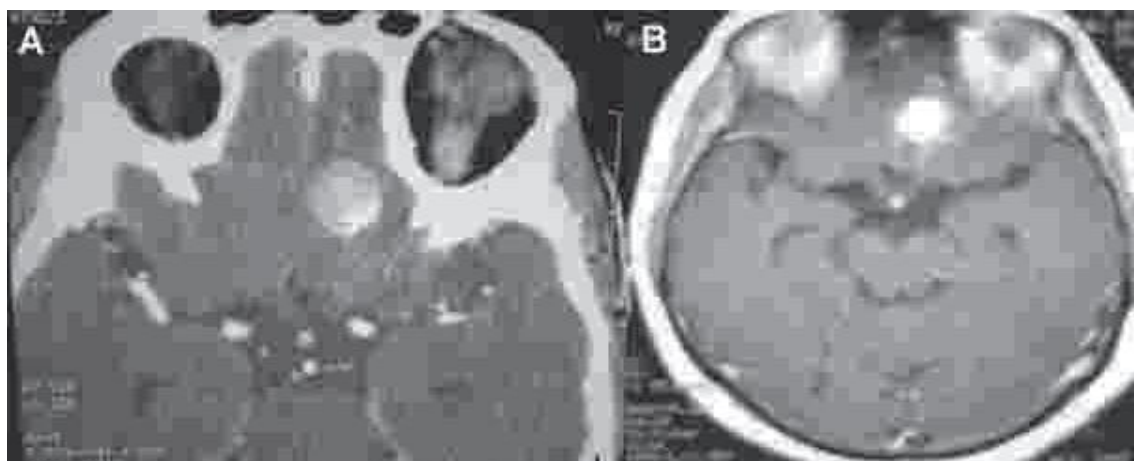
Contrast-enhanced CT (A) and MRI (B) showing small lesion in the left anterior cranial base with strong homogeneous enhancement.
